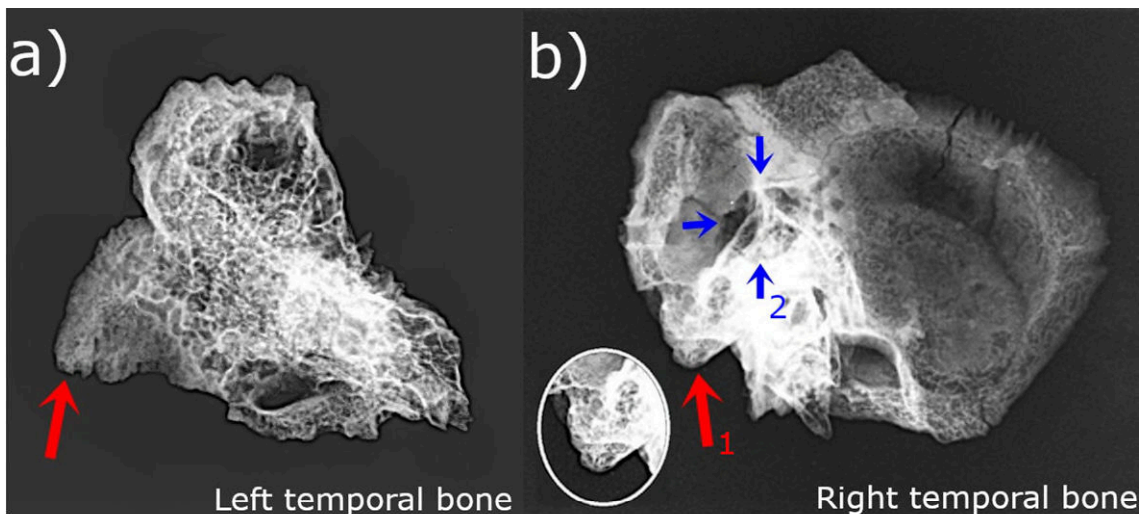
Radiograph of the temporal bones 60kV x6.4mAh. a) Lateral view of the left temporal bone. Arrow points to the mastoid process. b) Lateral view of the pathological right temporal bone. The mastoid air cells show diploic bone. Arrows point at the mastoid process (1), which is amplified inside the circle, and the borders of the perforation (2).
